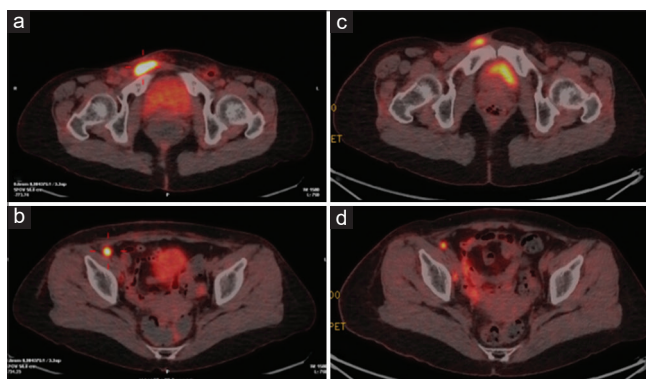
Positron emission tomography/computed tomography (PET/CT) scan of second recurrence. Fluorodeoxyglucose-avid tumors in the right inguinal region (a), right common iliac regions, and external iliac regions (b). After 4 cycles of immunochemotherapy, the PET/CT scan showed a partial response (c and d)
